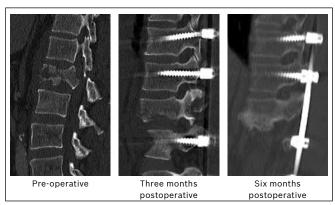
Serial CT images of an L1 burst fracture treated with PPSF technique. There is sclerosis noted within the fracture site, indicating bone healing and further stabilisation of the fracture.
